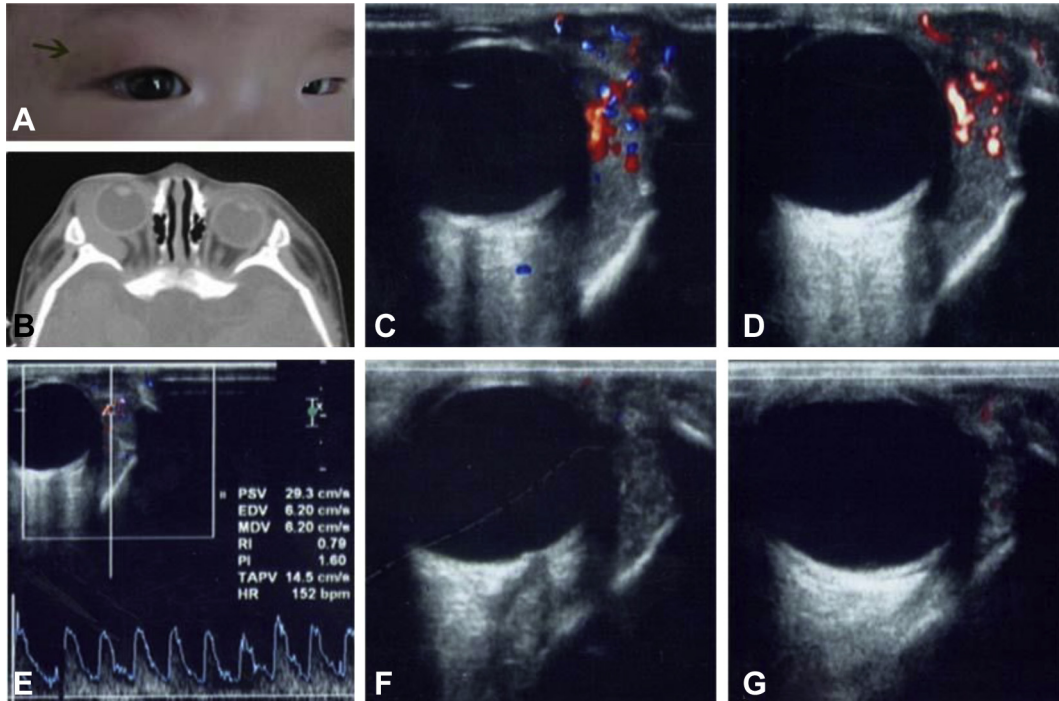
(A) A 6-month-old male patient shows temporal upper eyelid subdermal lesions presenting with bluish/purplish hue (arrow). (B) Computed tomography (CT) axial image shows infraorbital, extraconal soft-tissue-density masses. (C, D) Color Doppler flow imaging (CDFI) and color Doppler power imaging (CDPI) show the high-flow vascular lesion. (E) The pulse Doppler shifting shows high speed and high resistance of blood flow; the resistance index (RI) is 0.79. (F) CDFI 4 months after the third intralesional injection shows that the lesion has almost completely disappeared. (G) CDPI 4 months after the third intralesional injection shows that there is no signal on the CDPI.
